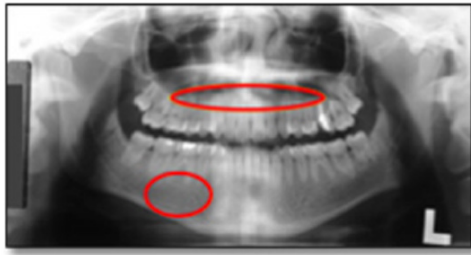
Density Assessment. Regions on a panoramic radiograph to look at to determine adequate density.
